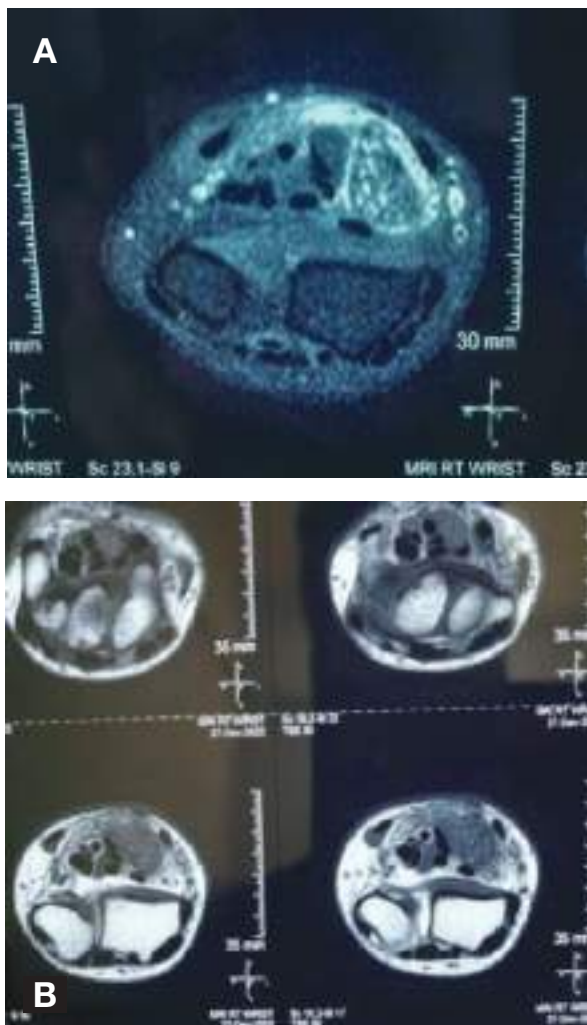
(A, B): Magnetic resonance imaging (MRI) scan. Axial sagittal short tau inversion recovery (STIR) images showing “cable-like” appearance of the nerve fibres at level of the wrist with the thickened nerve and maintained fibrillar pattern. Surrounding oedema was seen due to pressure effects. MRI scan of T1 axial images showing fibrofatty intensity within the enlarged thickened nerve
